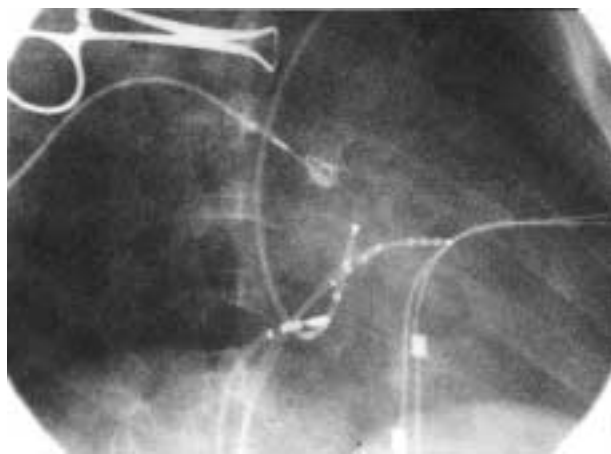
Radiographic representation of the ablation site in one of the studied patients. This right anterior oblique view shows the intracardiac catheters located in the right ventricle, in the His bundle region and in the coronary sinus. The tip of the ablation catheter is placed in the right postero-septal region, just beyond the anterior rim of the coronary sinus orifice.
